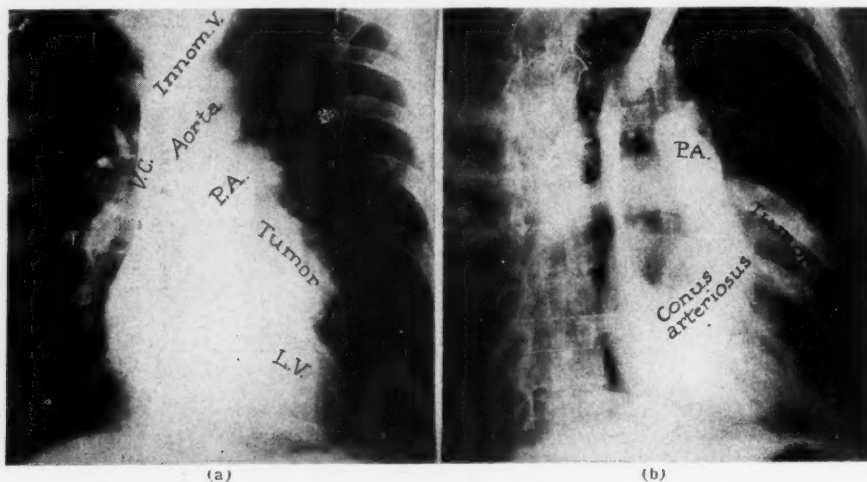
Roentgenograms of the heart. Diodrast was injected into a vein at the left elbow. (a) The innominate vein, the vena cava, and the pulmonary artery are shown. The tumor does not appear to communicate with any of the cardiac chambers. It is not an aneurysm. Calcification of the wall is present. (b) The right side of the heart wall is well visualized.
